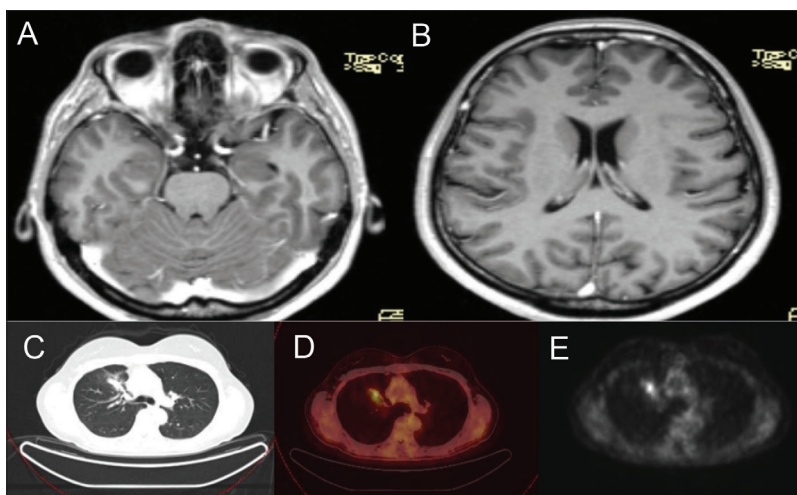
Magnetic resonance imaging of the brain performed after stereotactic radiosurgery procedure with no detectable lesions (A, B); positron emission tomography / computed tomography following ten cycles of systemic therapy, showing a maintained partial response to therapy and a significant radiopharmaceutical uptake in markedly reduced tumor mass (C, D, E)
